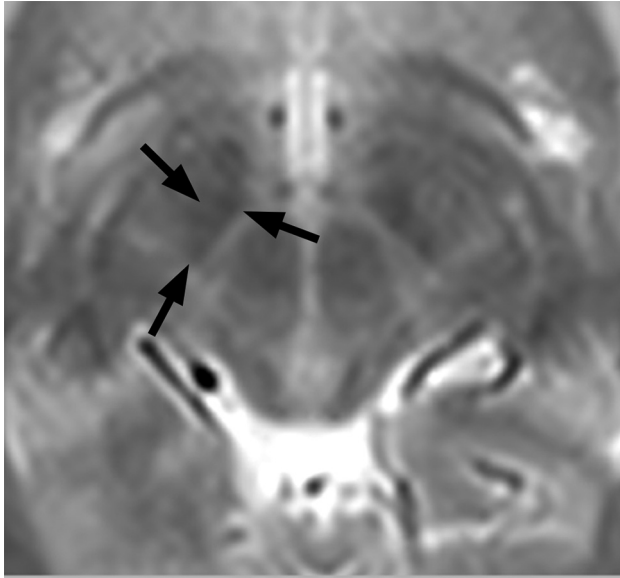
The smallest of the basal ganglia nuclei can be delineated on appropriate T2-weighted imaging through a region just cephalad to the midbrain. The subthalamic nucleus, a frequent target for deep brain stimulation, is outlined by arrows on the patient's right.
